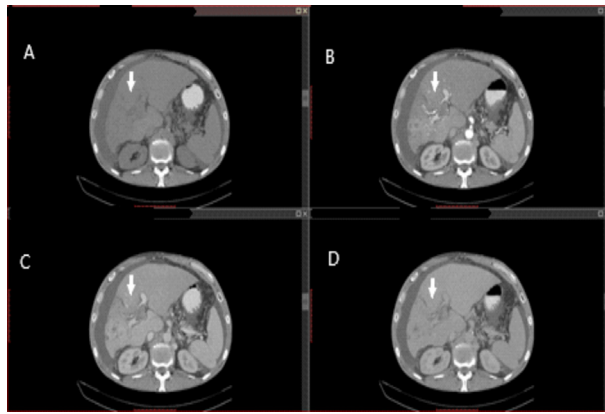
68-year-old man with multifocal HCC involving both right and left lobes of the liver, seen through successive CT phases. HCC: Hepatocellular carcinoma; CT: Computed tomography.
